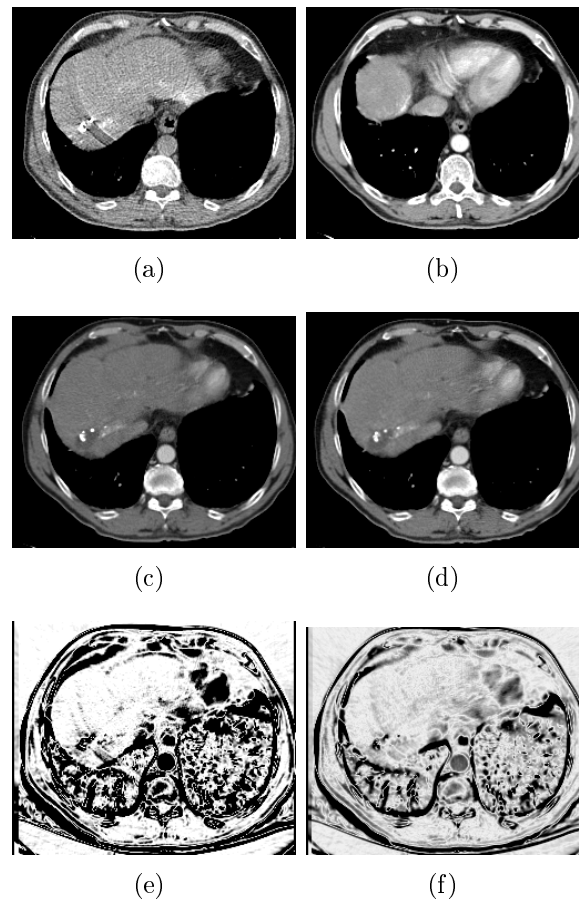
2D views of registration results on clinical data using M-estimator and AM-estimator. (a) shows the 2D CT-fluoro slice. (b) shows the initial pose in the CT-volume. (c) and (d) show the estimated minimum for the M-estimator respectively AM-estimator (e) shows the weights image at the minimum (dark for small weights and bright for high weights) for the M-estimator. (f) shows the weights image at the minimum (dark for small weights and bright for high weights) for the AM-estimator.
